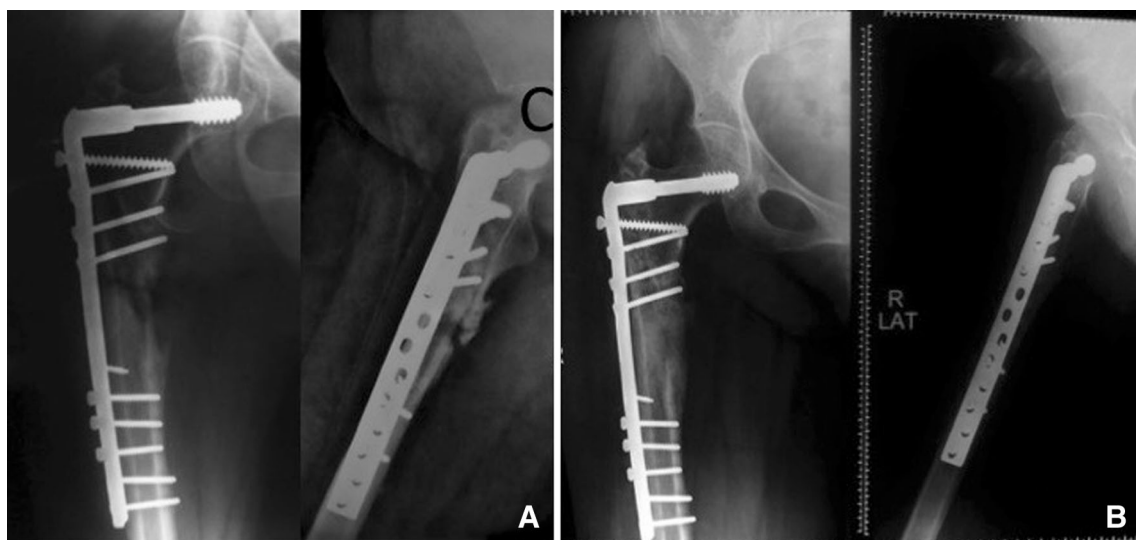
Preoperative radiographs of a subtrochanteric nonunion femur with dynamic condylar screw in situ (a), 12 weeks post-PRP injection radiographs showing good union (b)
